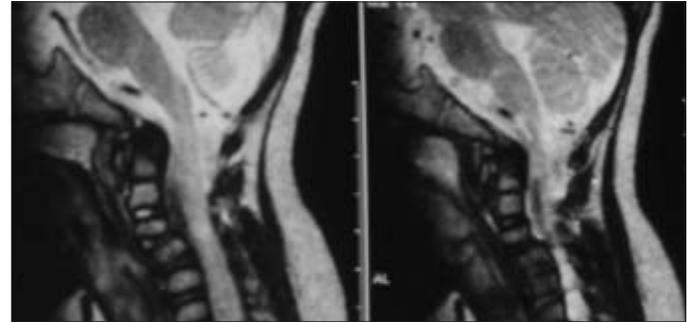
Magnetic resonance image of cervical spine.
